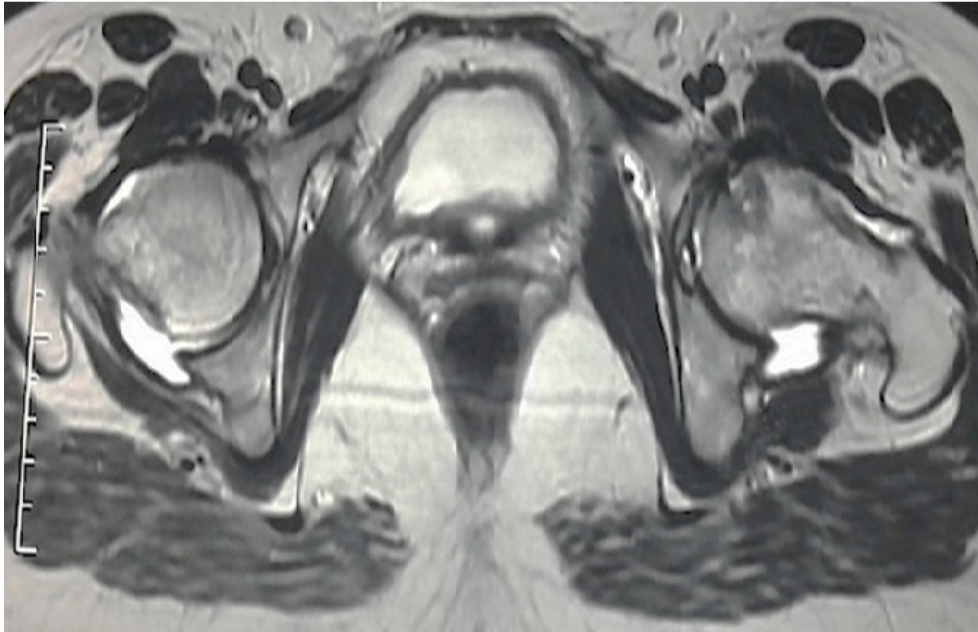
T2-weighted sequence MRI of the femoral heads showed bilateral joint effusion with focal lesion at the anterior part of the left hip
